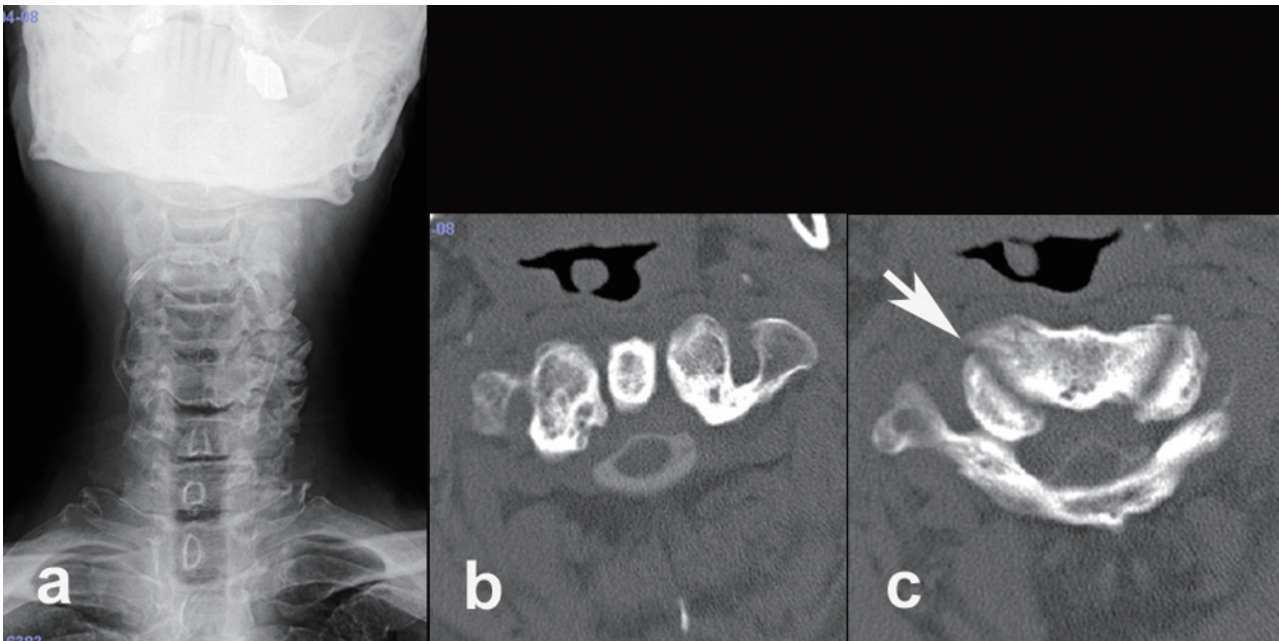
a. Plain radiogram showing the torticollis and spondylosis on the left side. b, c. Preoperative computed tomography (b: at the level of middle of C1 lateral mass, c: at the level of base of odontoid process) showing atlantoaxial rotary fixation and osteoarthritis of facet joint (Arrow).
